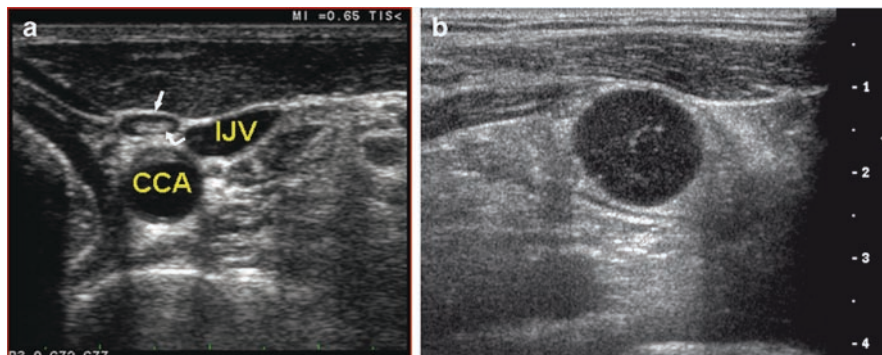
Sonographic findings in normal and metastatic nodes. (a) Axial ultrasound image shows normal oval node (*straight arrow*), with organized central internal echoes (*curved arrow*). The common carotid artery (CCA) and internal jugular vein (IJV) are labeled. (b) Nodal metastasis with round shape, internal hypoechoic appearance, and absence of the normal central echoes seen in (a). (Images courtesy of Beth S. Edeiken, M.D.)
